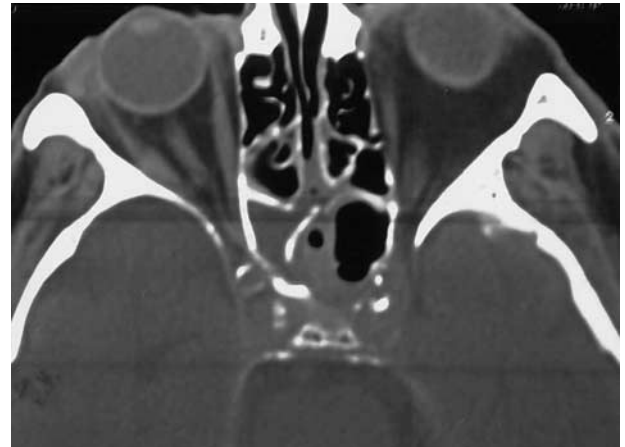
Postoperative axial CT scan showing complete removal of the mucocele from the sphenoidal cavity.
